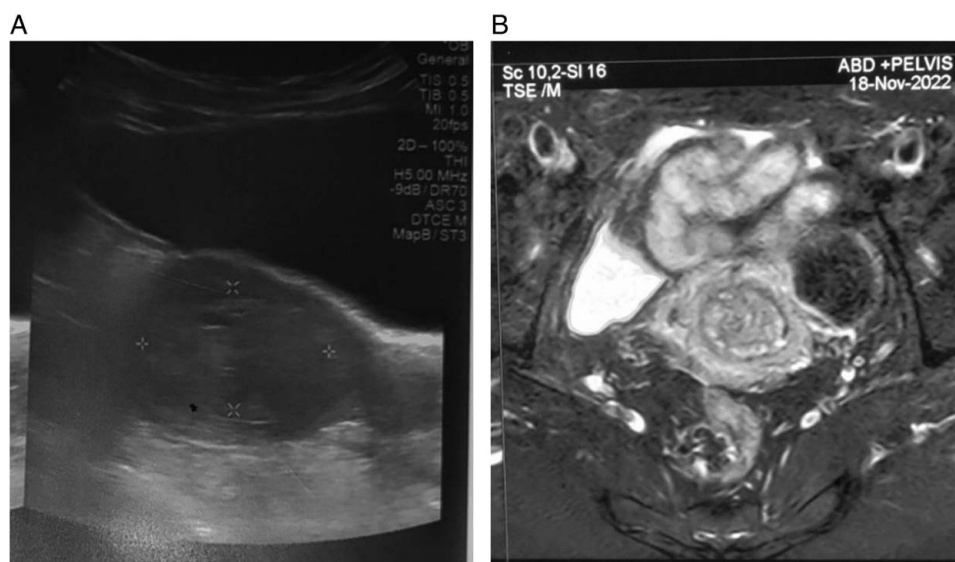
(A) Ultrasonography of the abdomen and pelvis showing thickened endometrium. (B) MRI of abdomen pelvis showing uterine fibroid in left anterolateral uterine body and endometrial polyp in the uterine cavity.
